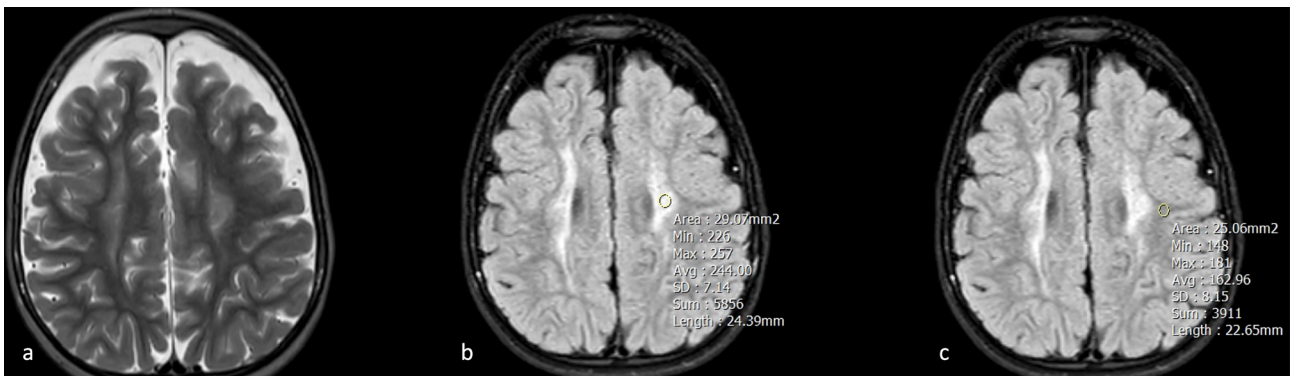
The FLAIR signal ratio measurement in a PVL case: Signal intensity measurement method with ROI from periventricular abnormally high signaled white matter (b) and adjacent normal signaled white matter (c) in axial FLAIR images
